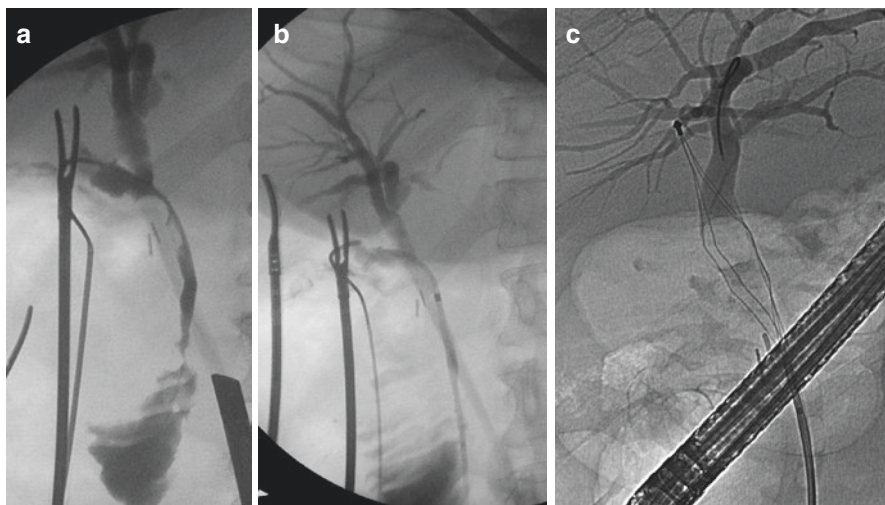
A 58-year-old man with Childs-Pugh A cirrhosis due to hepatitis C presented with acute cholecystitis and raised bilirubin. An ultrasound confirmed multiple gallbladder stones. (a) Operative cholangiogram revealed a stone still in the cystic duct or at the junction of the cystic duct and common hepatic duct. The common bile duct had not yet dilated. This stone was not able to be milked out of the cystic duct. Consideration to opening down the cystic duct was given, but decided against due to the concerns about possible bleeding, common bile duct injury and possible vascular injury. (b) A transcystic stent was inserted and the cholecystectomy completed. (c) An ERCP 4 weeks later found the stone in the common hepatic duct with a still non-dilated common bile duct. The stone was pushed proximally, captured in a lithotripsy basket, crushed and the fragments removed. Had this been unsuccessful an alternative technique would have been endoscopic laser lithotripsy
